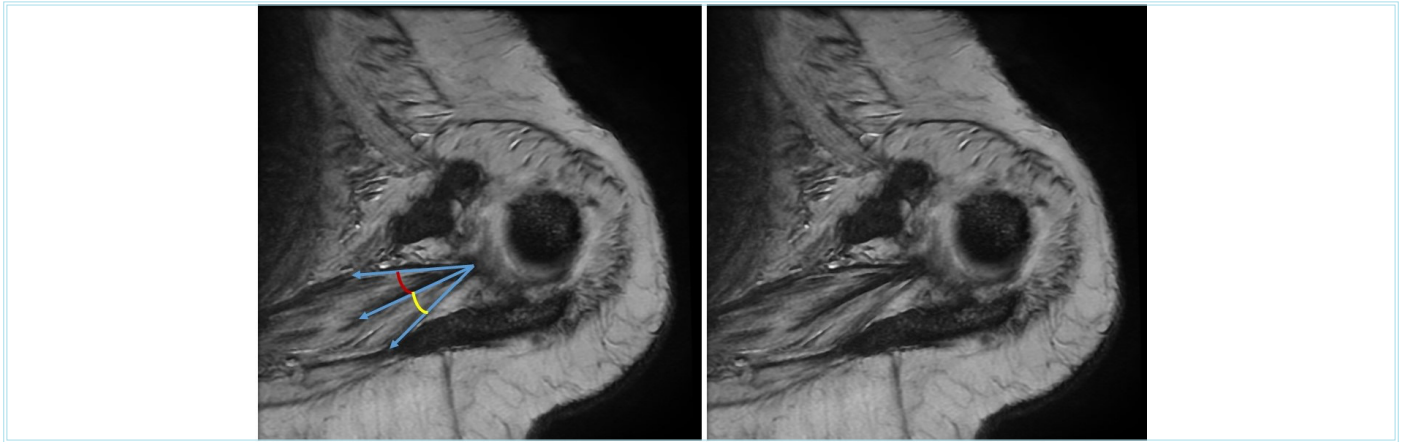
Magnetic resonance imaging axial gradient inversion recovery sequence of the left shoulder joint showing the anterior pennation angle (red arc) and posterior pennation angle (yellow arc)
